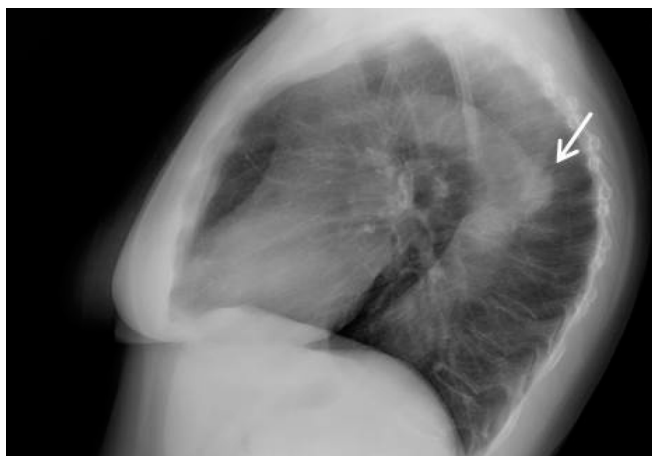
Lateral chest x-ray with a focal posterior convexity (arrow) projecting from the proximal descending aorta.
